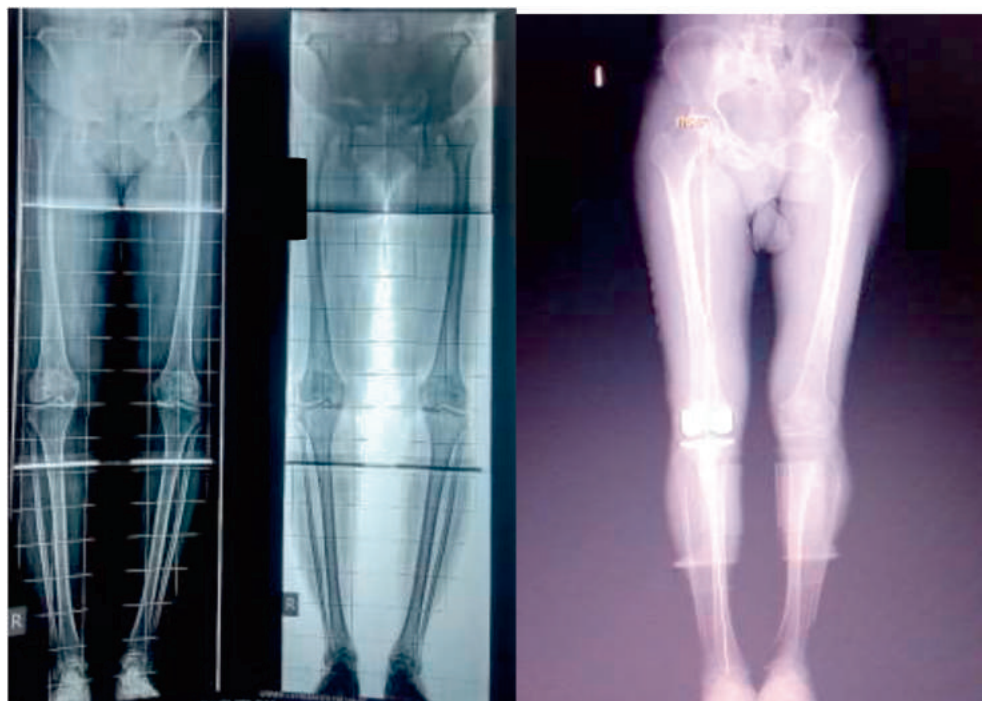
Depicts long lower limb radiographs and measurement of mechanical axis Pre Operative and Post operative.
